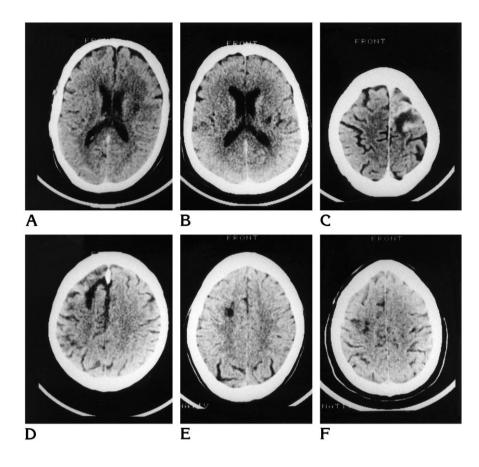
Representative CT scans of 12 patients with territorial strokes, selected to depict the largest extent of the stroke in each patient, show territorial infarctions of the middle cerebral artery (A–H), nucleus lentiformis infarction (I), and territorial infarctions of the posterior cerebral artery (J–L). G, H, and L show acute disruption of the blood-brain barrier after contrast enhancement.
